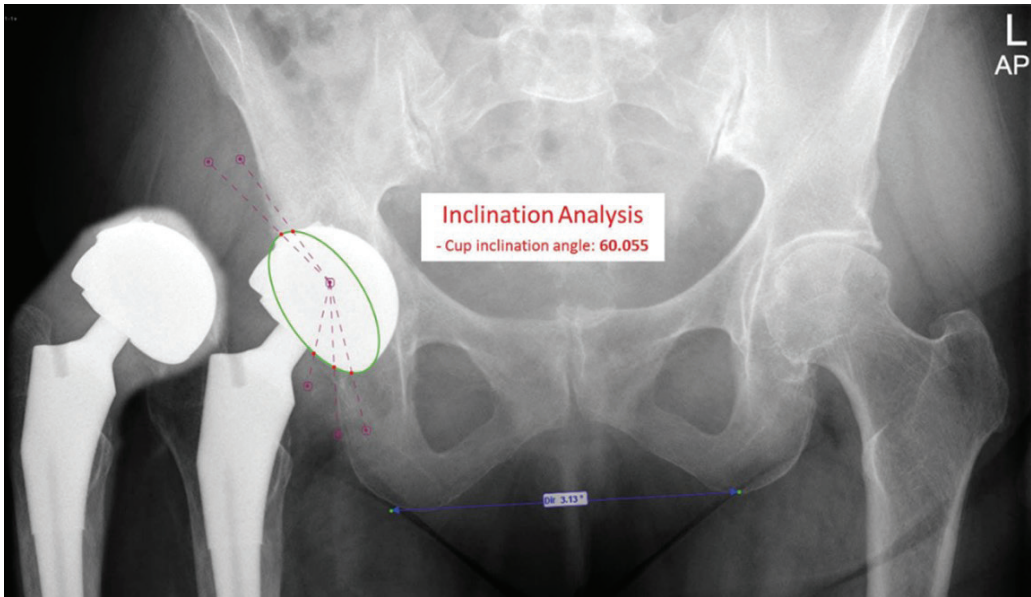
Anteroposterior radiograph of the pelvic from patient no 2 with the MoM total hip replacement on the right. The acetabular inclination angle was estimated 60 degrees and the anteversion angle 31 degrees.
